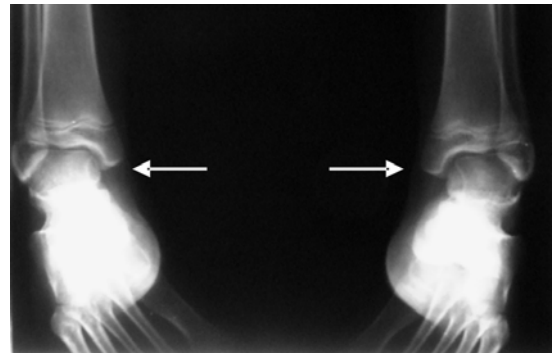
X-ray foot, medial plane view
